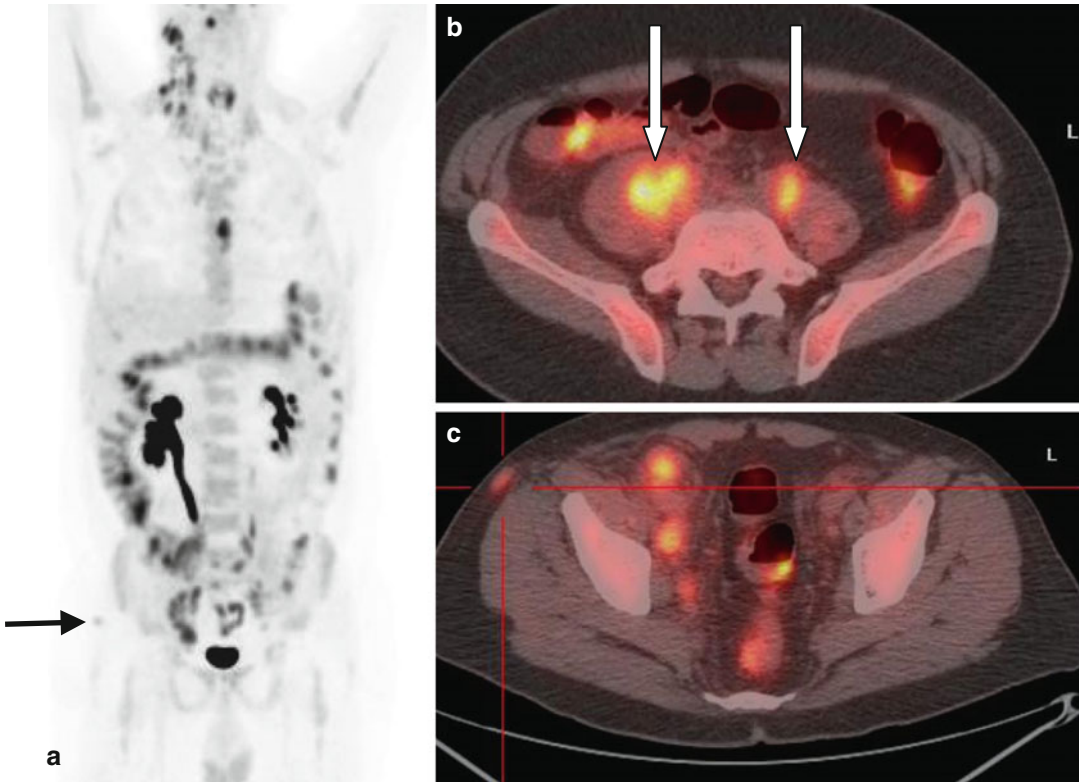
(a–c) PET/CT staging demonstrated extensive lymphadenopathy with abnormal 18-FDG uptake (SUVmax 12) and increased metabolic activity of the psoas lesion (SUVmax 8.7) in extension of right iliac
